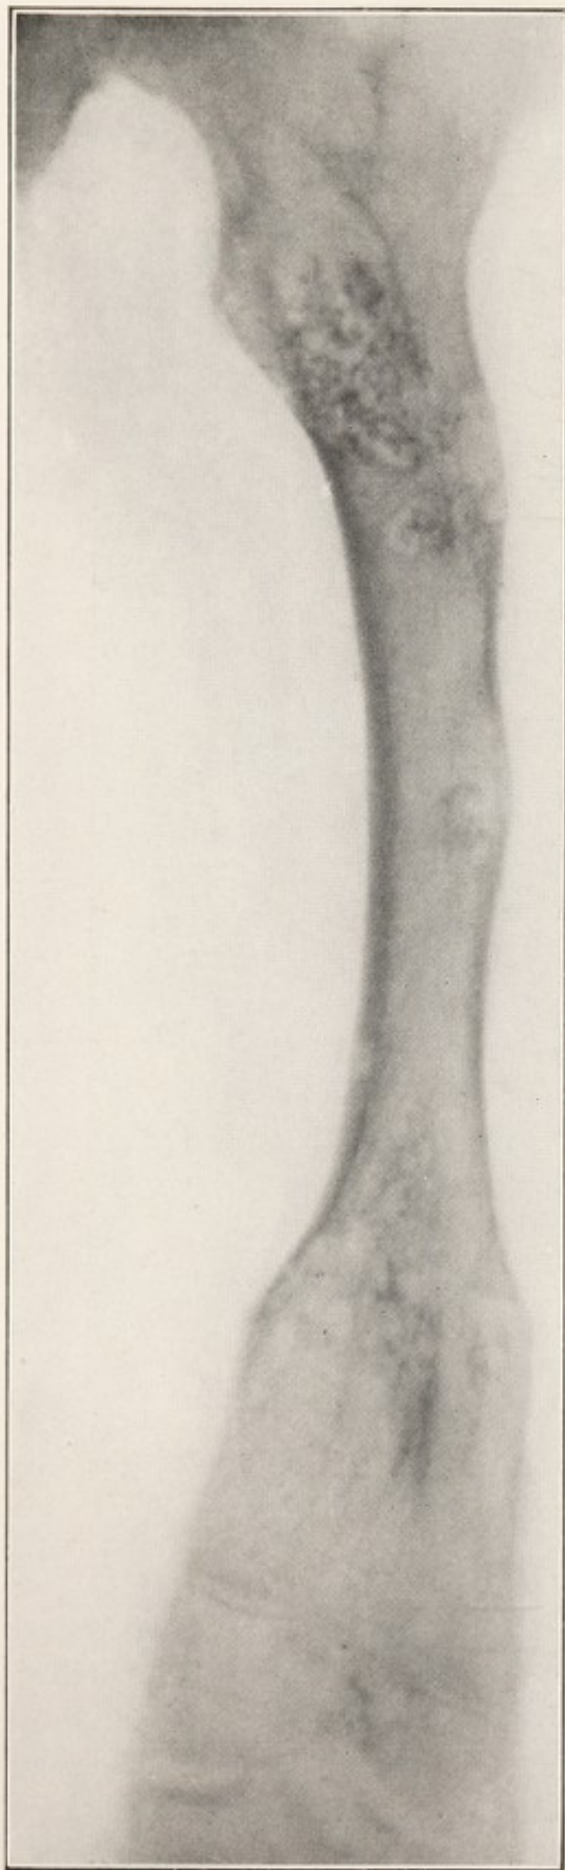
X-RAY SHOWING TYPICAL DYSCHONDROPLASIA OF FEMUR WITH METAPLASIA; ALSO INVOLVEMENT OF TIBIA.
